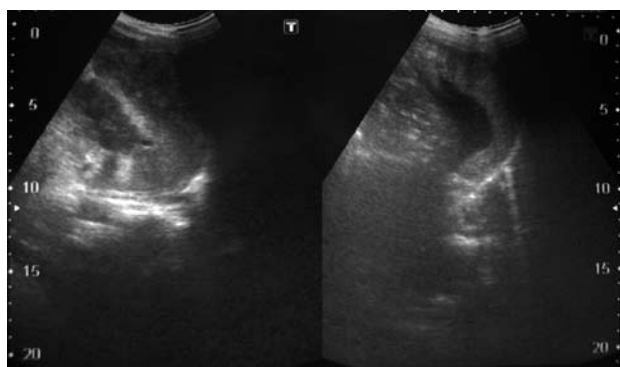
Abdominal ultrasonography of case V revealed a hyperechoic mass composed of spleen and perisplenic fluid.
